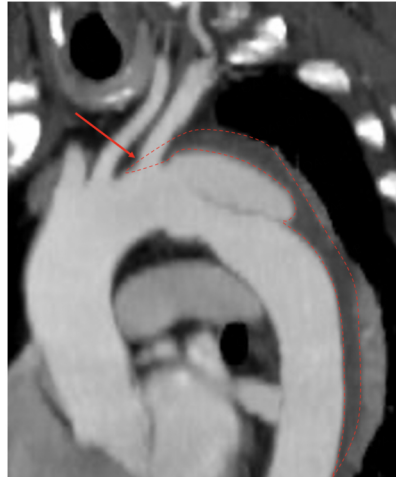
CTA with multiplanar reconstruction of an intramural hematoma, complicated by a focal type B dissection, with hematoma extension in the aortic arch.
